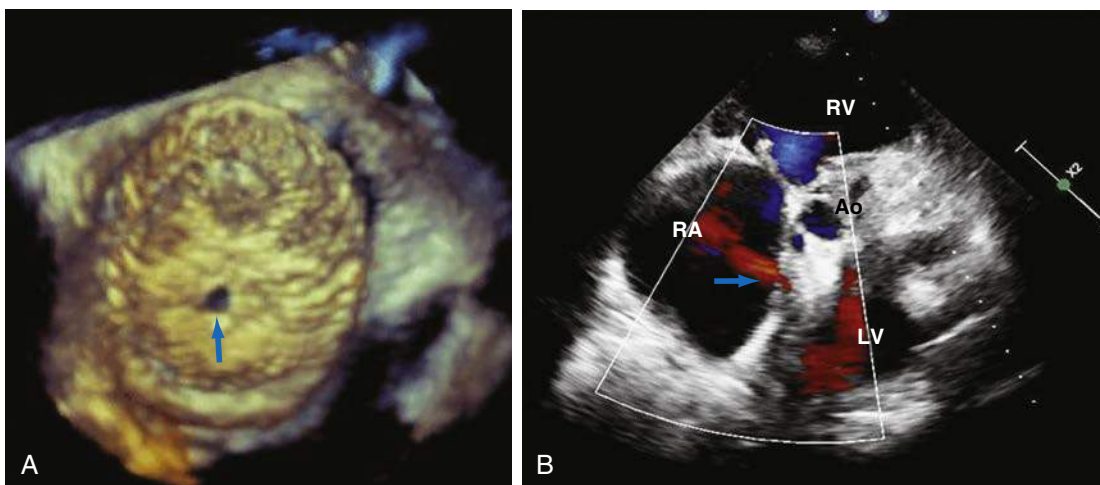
Images from a patient with a large atrial septal defect and pulmonary arterial hypertension after closure with a fenestrated device. A, Three-dimensional transesophageal echocardiogram (3D TEE) imaging showing a fenestrated device closing the atrial septal defect (ASD); the *blue arrow* points to the fenestration on the ASD closure device. B, Two-dimensional transthoracic echocardiography (2D TTE) from the parasternal short-axis view; color Doppler demonstrates a left-to-right shunt through the fenestration (*blue arrow*). Ao, Aorta; LV, left ventricle; RA, right atrium; RV, right ventricle.
